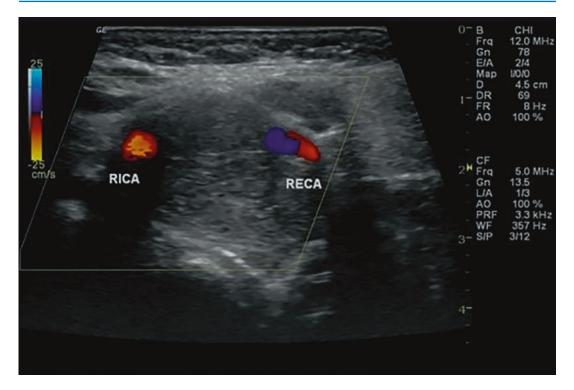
Glomus tumor of the bulb at the level of carotid bulb and the bifurcation area vertical to the arterial flow demonstrating with the use of color Doppler disturances
